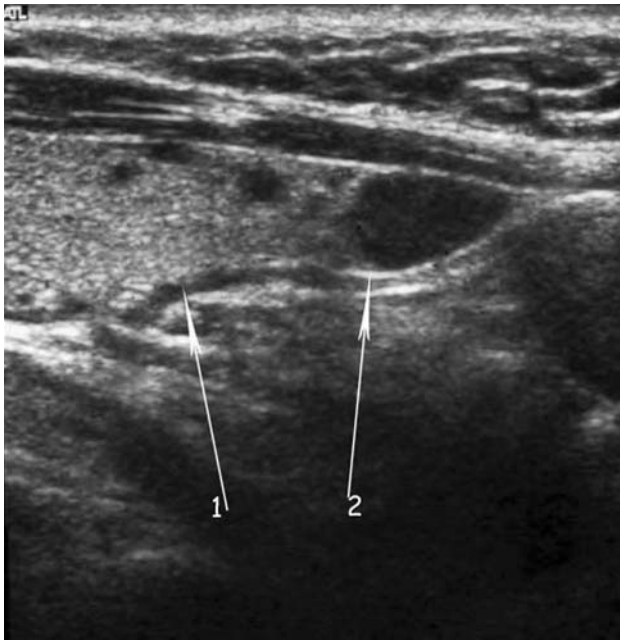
Ultrasonography. Arrow 1: Right thyroid lobe. Arrow 2: right inferior parathyroid adenoma just below the tip of the inferior pole of thyroid lobe and in the superficial plane: position 3
